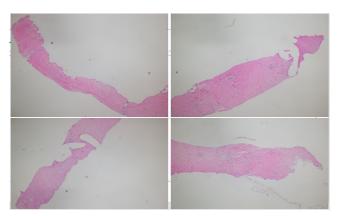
CT-guided biopsy of the mediastinum, showing hyalinization, March 2025.
